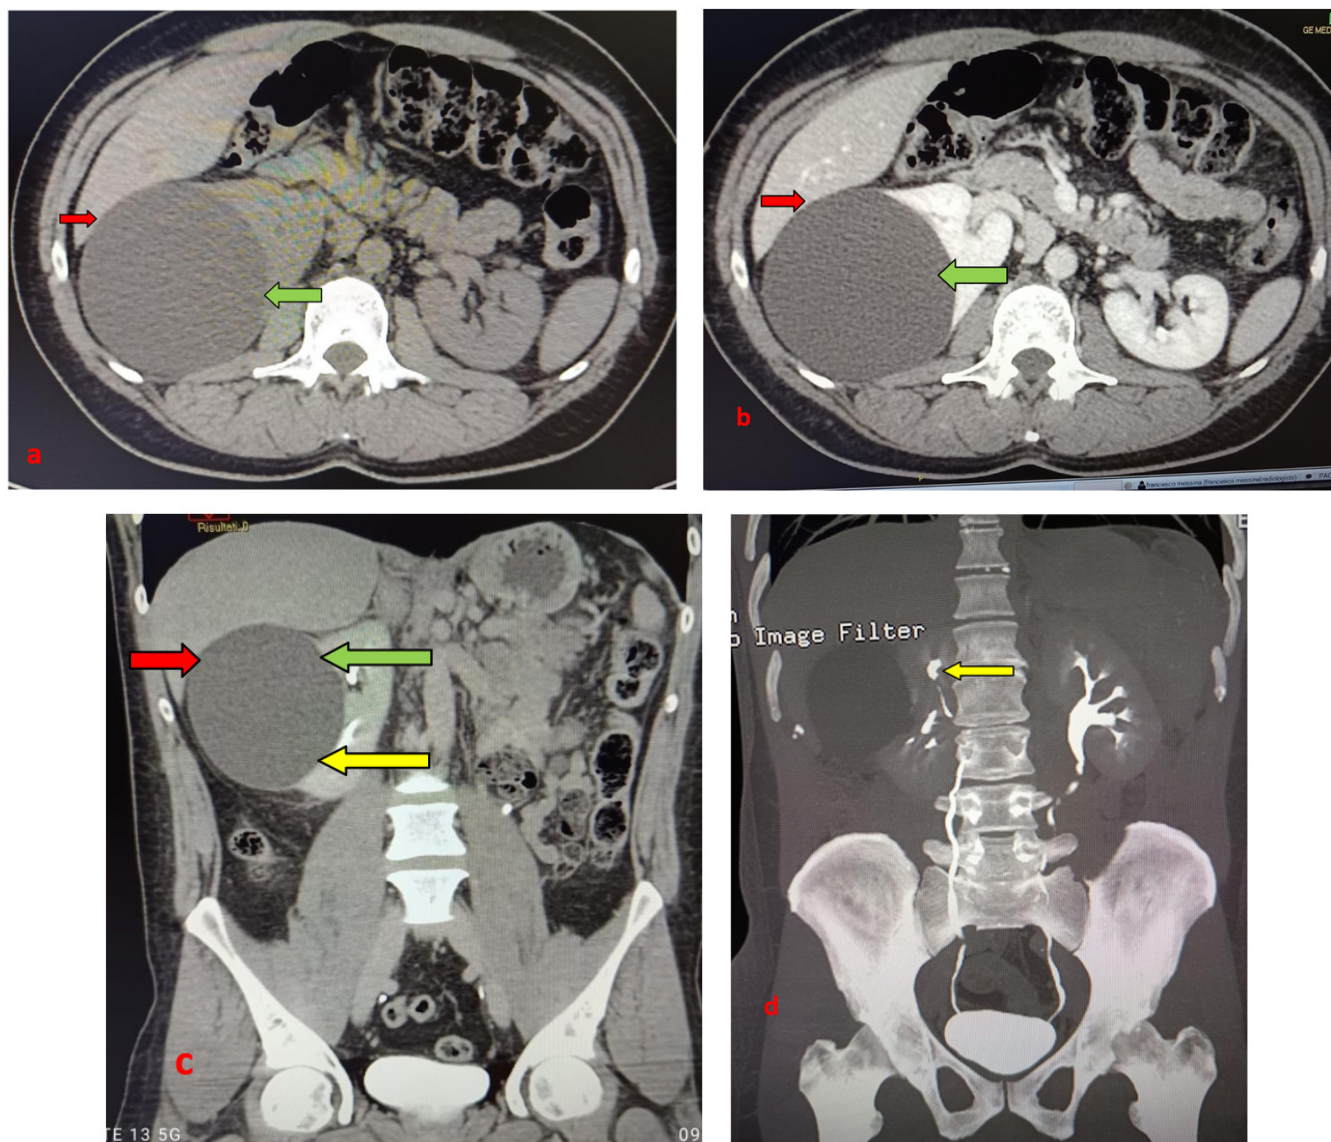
(a-d): CT-urography with Uro-CT scan protocol. Basal phase (a); axial reconstruction. Basal phase (a); cortico-medullary phase (b) ; nephrographic phase (c) and excretory phase (d) with a MIP coronal reconstruction. CT had shown the presence of a giant renal cyst (10 cms) in the renal cortex of the right kidney (green arrow), with hypodense appearance, exophytic development, without any contrast enhancement in the various phases of the CT study. CT-urography had also shown the presence of a compression at the same time with the lower margin of the right hepatic lobe (red arrows), and a compression of the proximal section of the right ureter (yellow arrows).
